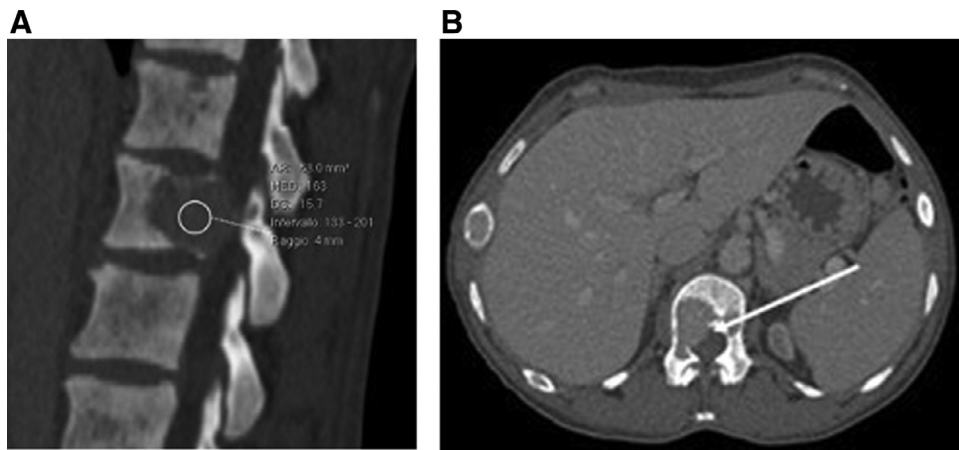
Sagittal and axial CT scan demonstrating the presence of soft tissue mass involving the body of L1 characterized by attenuation values in the range of fibrous tissue (2A). The arrow shows the mass extension in the spinal canal (2B).
